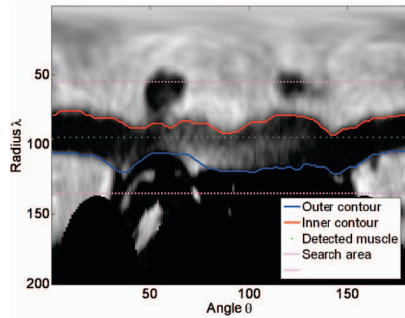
An MR image in systole transformed into polar coordinates.
